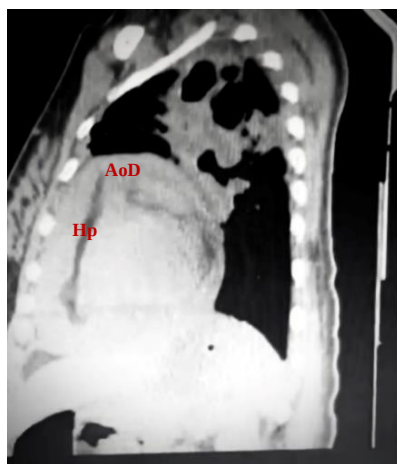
Sagittal section of a plain chest CT scan
